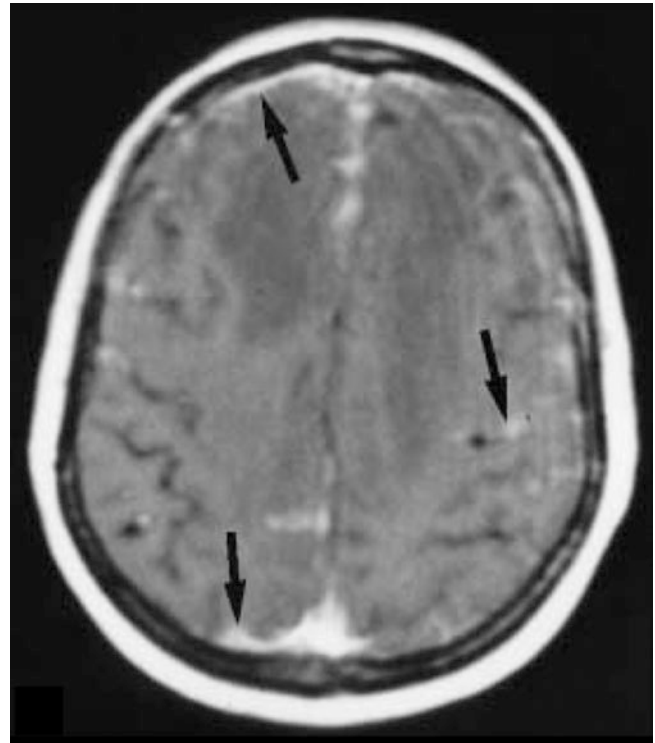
Magnetic resonance image of rheumatoid pachymeningitis. MRI brain with contrast-enhanced T1-weighted image showing sulcal effacement with patchy meningeal thickening and contrast enhancement (arrows). (Reprinted with permission from Cellerini et al. [9])
